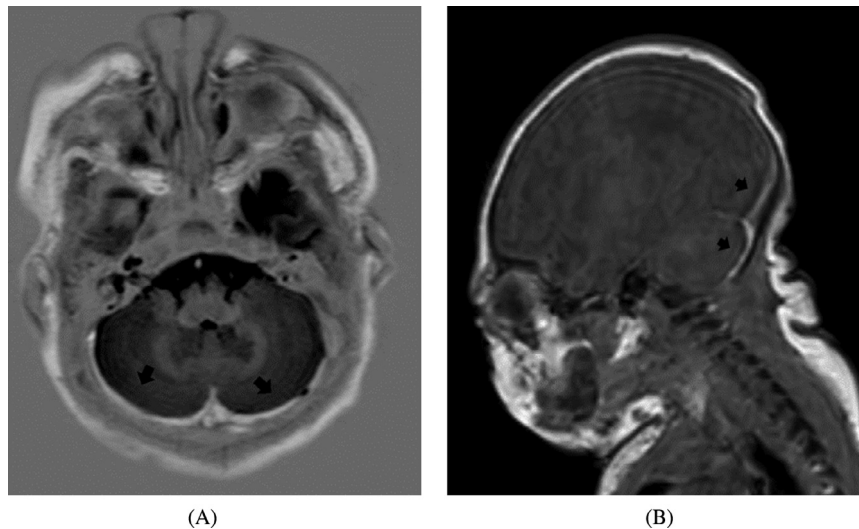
SDH in a newborn. (A) axial T1 IR and (B) sagittal T1 images from a brain MRI examination performed on a 4-day old newborn female who presented with a seizure, demonstrate an incidental finding of an SDH in the occipital region and in the posterior fossa (arrows). No other abnormalities were identified on this examination.
